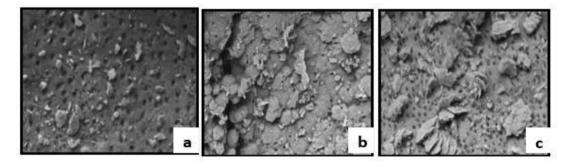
Group A – Chloroquick irrigation with ultrasonic agitation a) Coronal third; b) Middle third; c) Apical third
